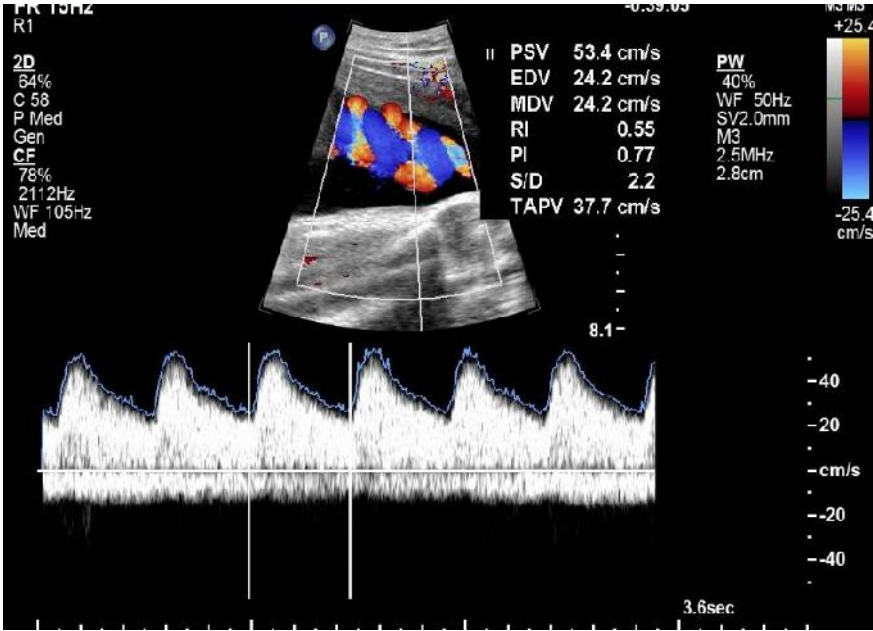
NORMAL UMBILICAL ARTERY DOPPLER
